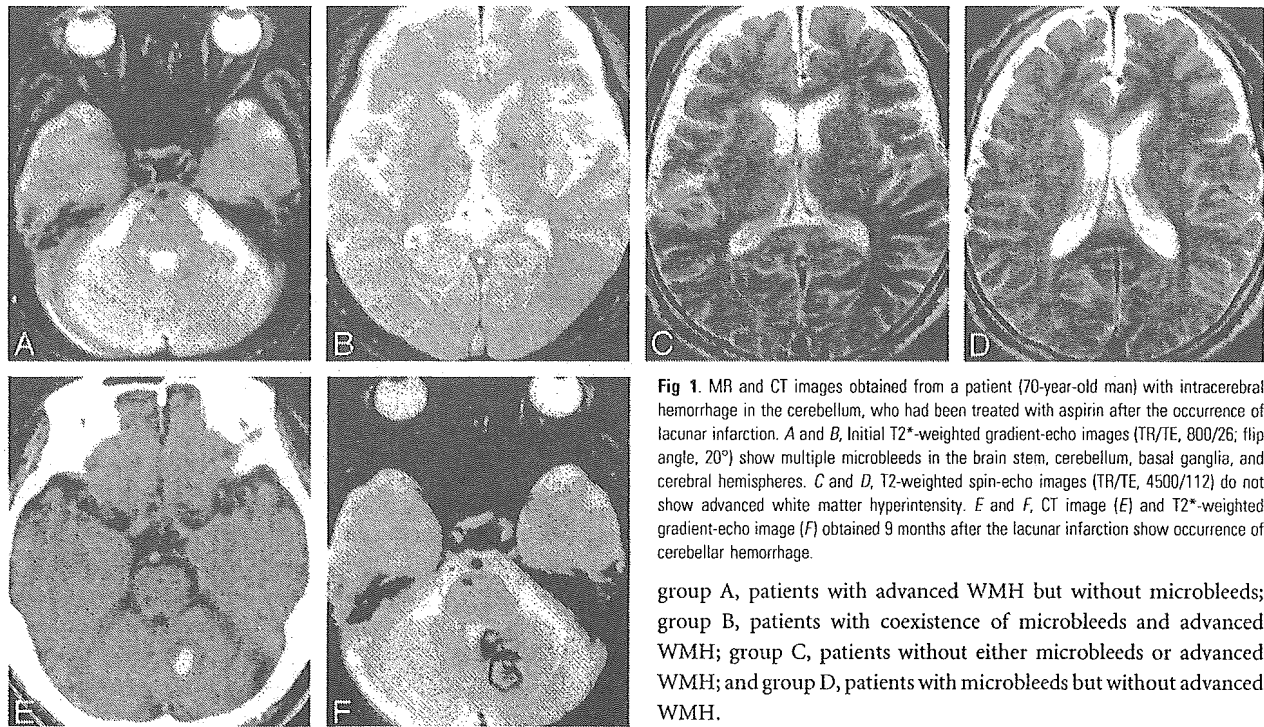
MR and CT images obtained from a patient (70-year-old man) with intracerebral hemorrhage in the cerebellum, who had been treated with aspirin after the occurrence of lacunar infarction. *A* and *B*, Initial T2*-weighted gradient-echo images (TR/TE, 800/26; flip angle, 20°) show multiple microbleeds in the brain stem, cerebellum, basal ganglia, and cerebral hemispheres. *C* and *D*, T2-weighted spin-echo images (TR/TE, 4500/112) do not show advanced white matter hyperintensity. *E* and *F*, CT image (*E*) and T2*-weighted gradient-echo image (*F*) obtained 9 months after the lacunar infarction show occurrence of cerebellar hemorrhage.
